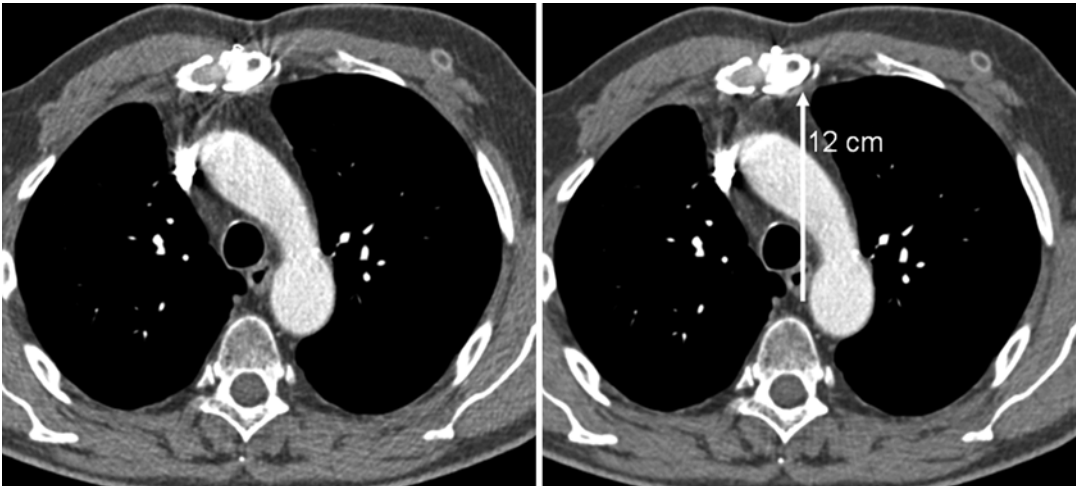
Reduction of spiral windmill artifacts in a 64-slice CT scan (left) with the z -flying focal spot technique (right, white arrow). The distance of the sternum from the isocenter is about 12 cm
